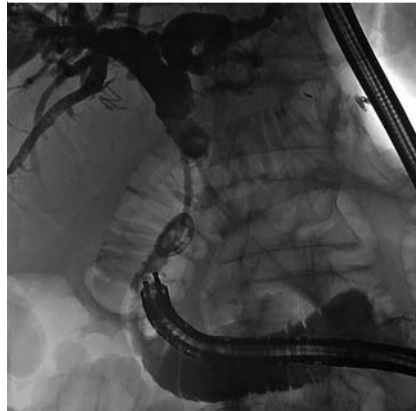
Abdominal radiograph after the internal-external biliary drain had been positioned.
